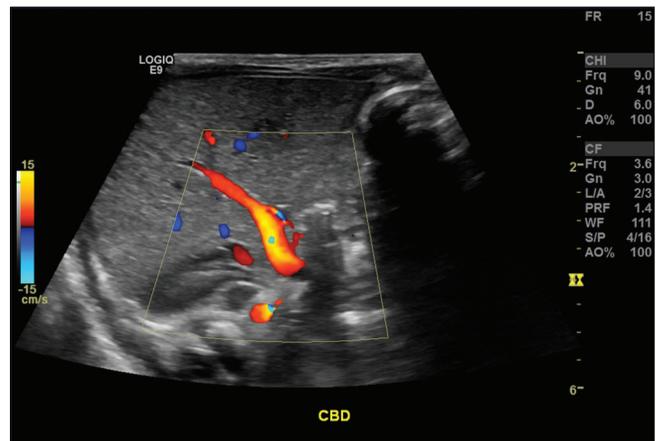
Abdominal ultrasound on day of life 54 showing normal liver, gall bladder, and common bile duct, without identified abnormalities
